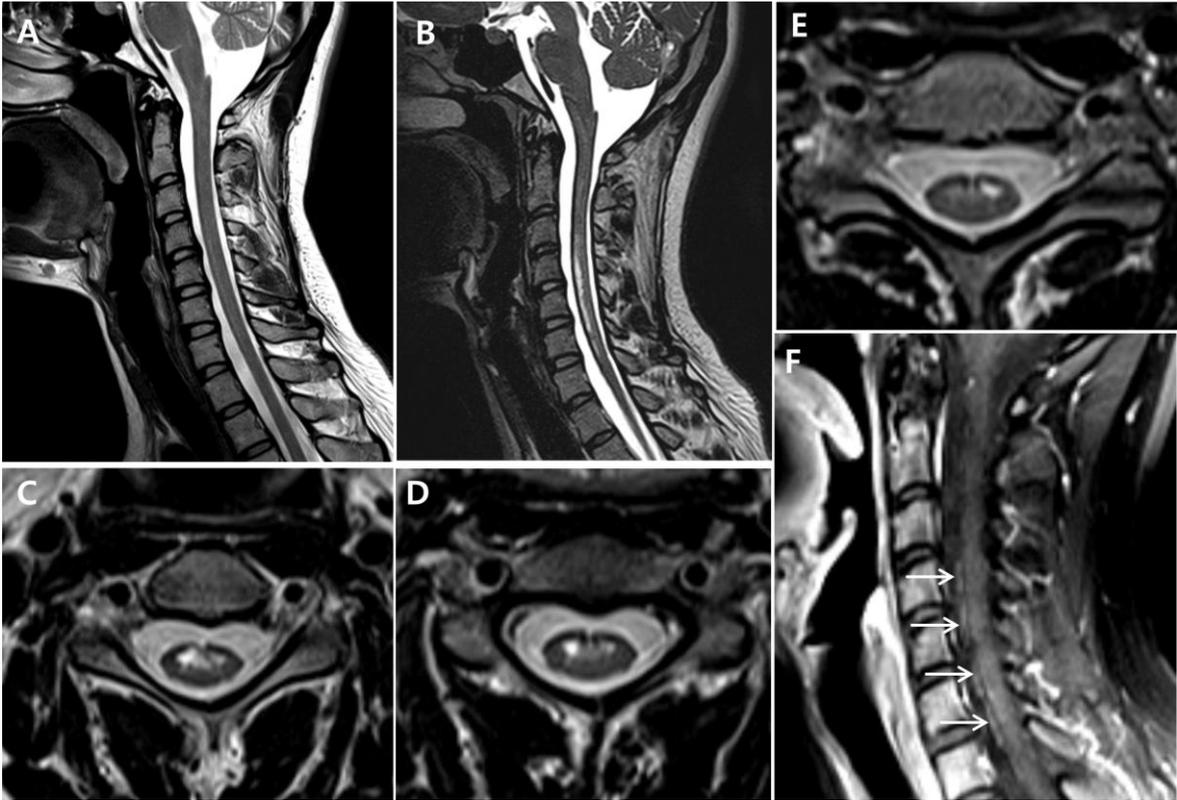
Magnetic resonance imaging (MRI) findings. (A) MRI scans within three hours of symptom onset revealed no definite abnormalities in cervical cord. (B) At 2 weeks after the onset of neurological symptoms, cervical spine MRI revealed T2-hyperintensity within the anterior spinal cord. (C-E) Axial T2 weighted image revealed prominent anterior horn cell involvement at C4 and 5 level on right and C6 level on left. (F) Gadolinium-enhanced T1 weighted image showed ventral root enhancement over C4-7 vertebral levels on paracentral area (arrow).
